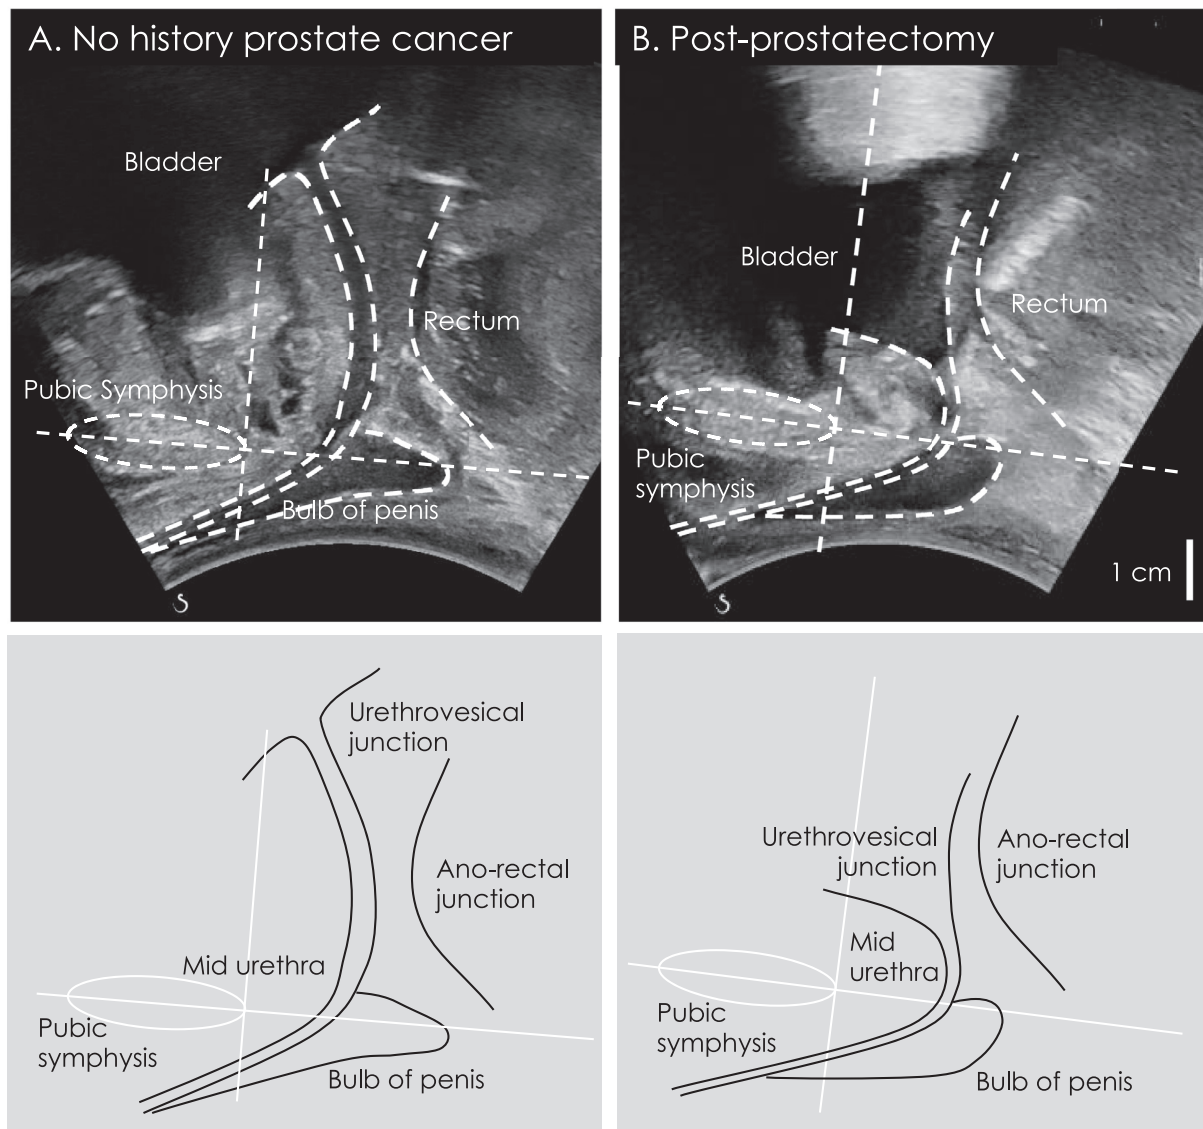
Transperineal ultrasound investigation of the striated pelvic floor muscles of (A) a healthy man with no history of prostate cancer and (B) a man after radical prostatectomy, both at rest. Note the lower position of the bladder, funneling of the bladder neck, and shorter urethral length of the man after prostatectomy.
